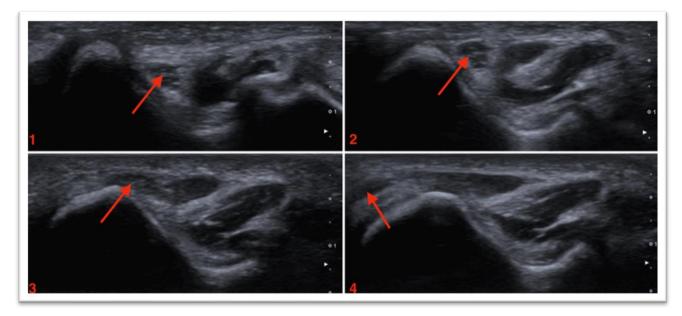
The patient exhibited an ulnar nerve dislocation (*red arrow*) during full forearm supination and maximum elbow flexion, as demonstrated by dynamic ultrasound testing.
